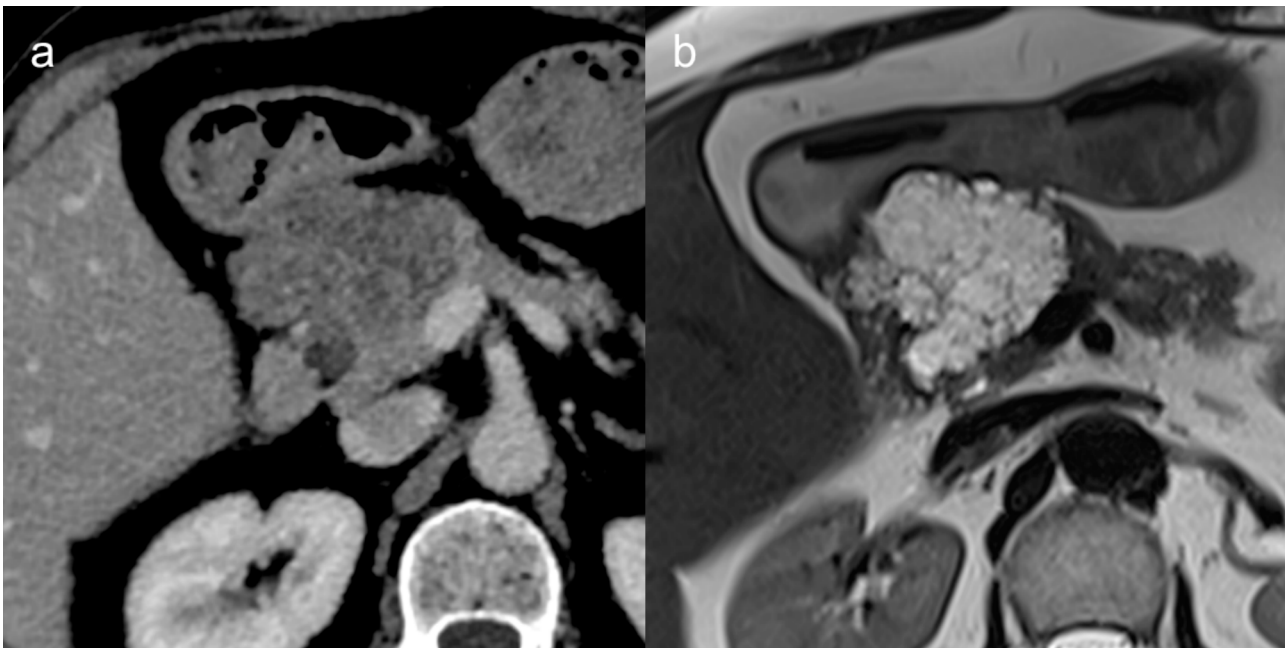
59-year-old female with serous cystadenoma. Contrast-enhanced CT (a) and MRI on T2-weighted image (b) show a lobulated lesion in the pancreatic head with microcystic appearance and high signal intensity of T2-weighted image.
